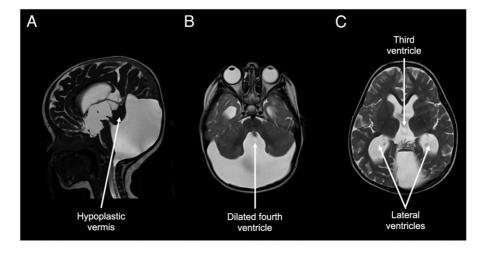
Congenital malformations often take time to manifest clinical symptoms of increased intracranial pressures. T2-weighted magnetic resonance image sequences of an 11-month-old with increasing head circumference demonstrating Dandy Walker malformation with the sagittal view showing hypoplastic vermis (A), the axial view showing a dilated fourth ventricle (B), and the axial view showing an enlarged ventricular system (C).
